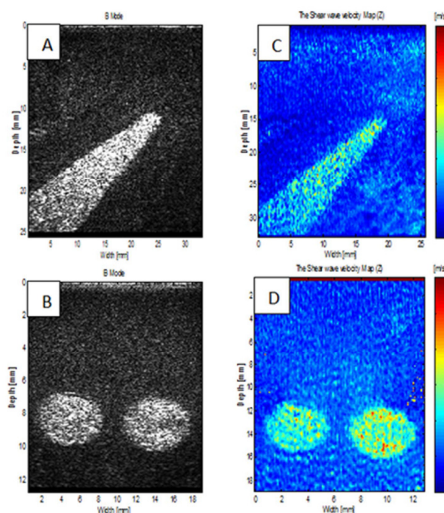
(A) and (B) Sonograms showing inclusions. (C) and (D) Shear wave speed maps. The contrast of the shear wave speed shows clearly the inclusions.
